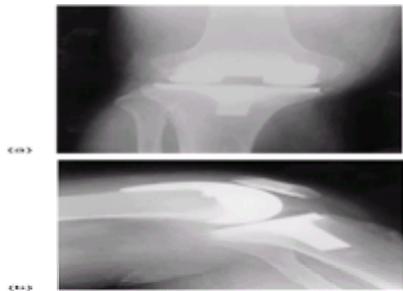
Anteroposterior (a) and lateral (b) radiographs showing a cemented total condylar knee replacement. The patella has been resurfaced.
